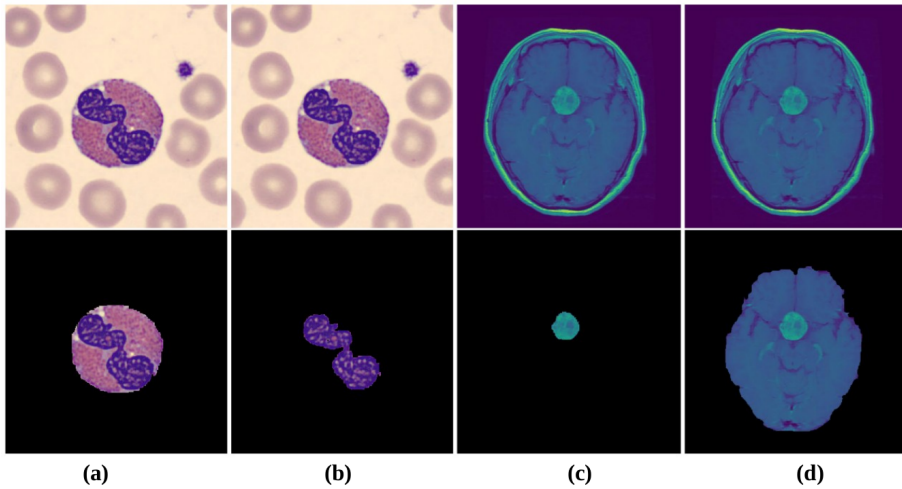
Examples of segmented images in second row. (a) *Segmented white blood cell (eosinophil cell)*, (b) *Segmented nucleus of eosinophil cell*, (c) *segmented tumor from the representative axial MRI section*, (d) *segmented brain from the representative axial MRI section*. Original images (row one) from [1] for WBC and [12] for MRI image.
